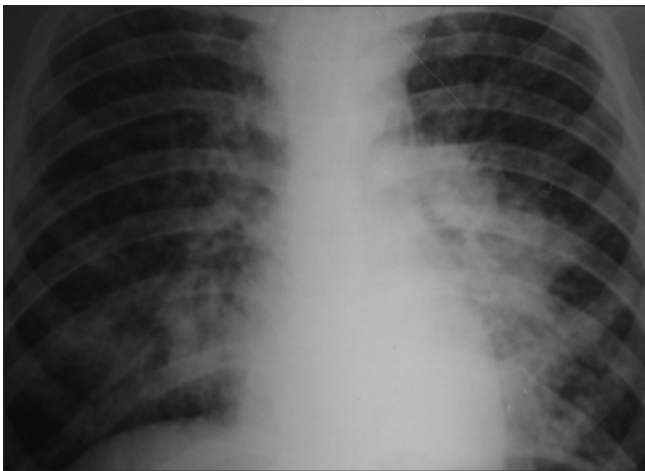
Chest X-ray PA view showing extensive, bilateral, mottled infiltrates in lung fields accompanied by mediastinal widening and prominent bronchovascular markings
